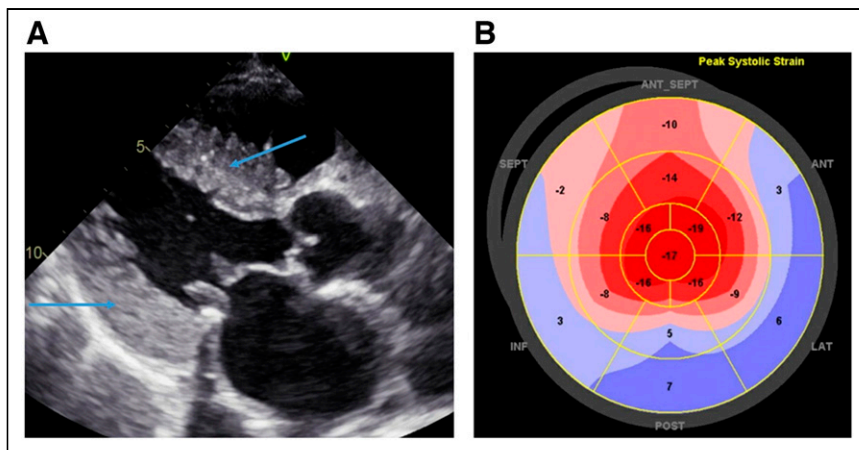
Echocardiogram cardiac amyloidosis findings. (A) Parasternal long axis view demonstrating severely increased left ventricular wall thickness in patient with cardiac ATTR (arrows). (B) Apical sparing (bull's-eye) pattern identified on longitudinal strain echocardiography from same patient. ANT = anterior; ANT_SEPT = anteroseptal; INF = inferior; LAT = lateral; POST = posterior; SEPT = septal. (Courtesy of Dr. Saurabh Malhotra.)
